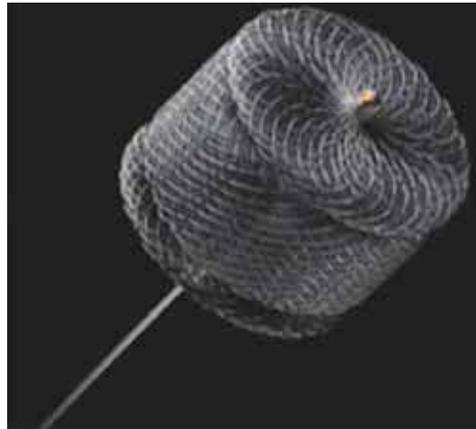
Commercially available Amplatzer Vascular Plug II (St. Jude Medical, Minneapolis, MN). The small diameters and lengths of this device, easy deliverability and excellent fluoroscopic and echocardiographic features of this device are attributes desirable in a PDA device in small neonates.
